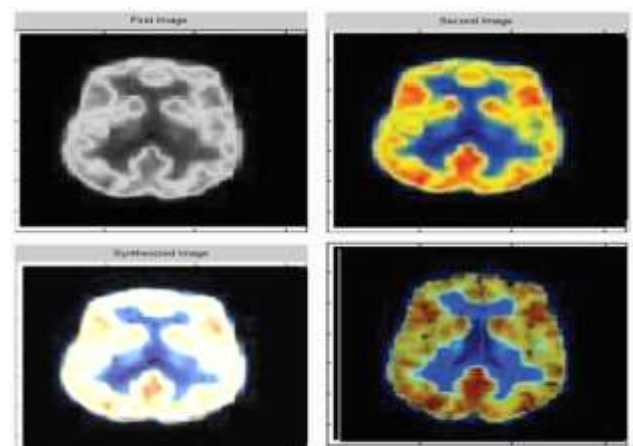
Fused image of MRI and PET normal Image
